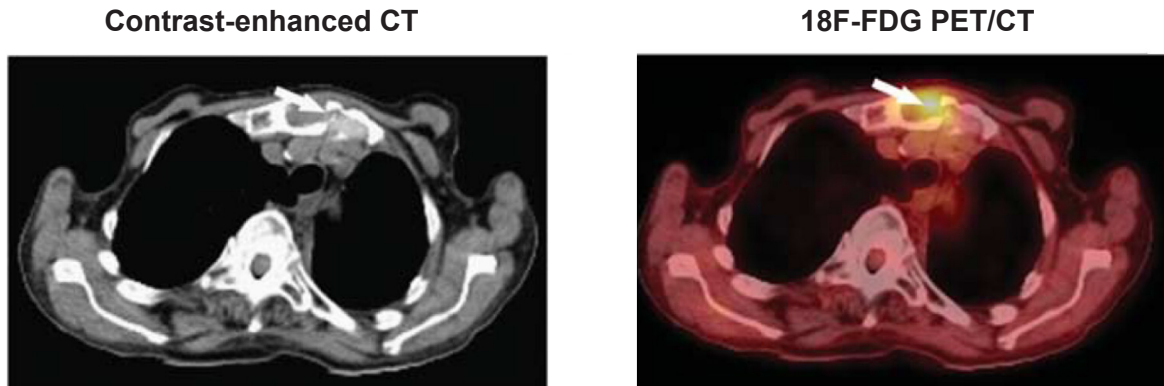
Accumulation in contrast-enhanced 18F-FDG/CT in a 79-year-old patient with bone metastasis from NSCLC (arrow: metastasis focus), pathologically confirmed as metastatic lymph node.
